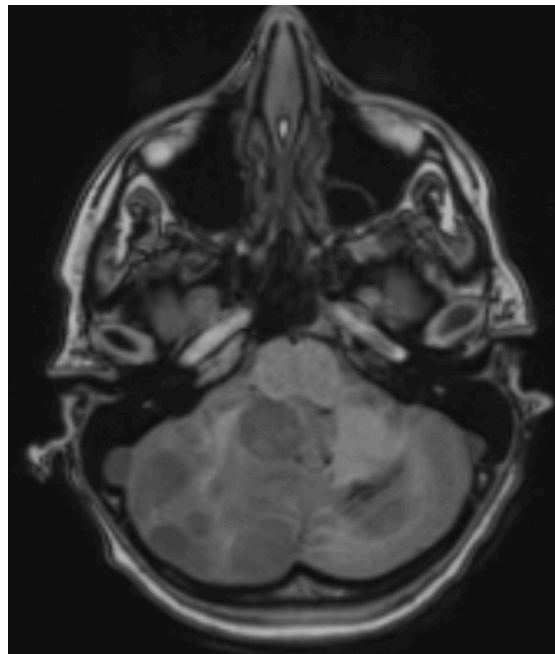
Axial T1-weighted MRI at the level of the posterior fossa demonstrating a heterogeneously lesion within the right cerebellar hemisphere. The lesion produces localized distortion of adjacent cerebellar folia.
